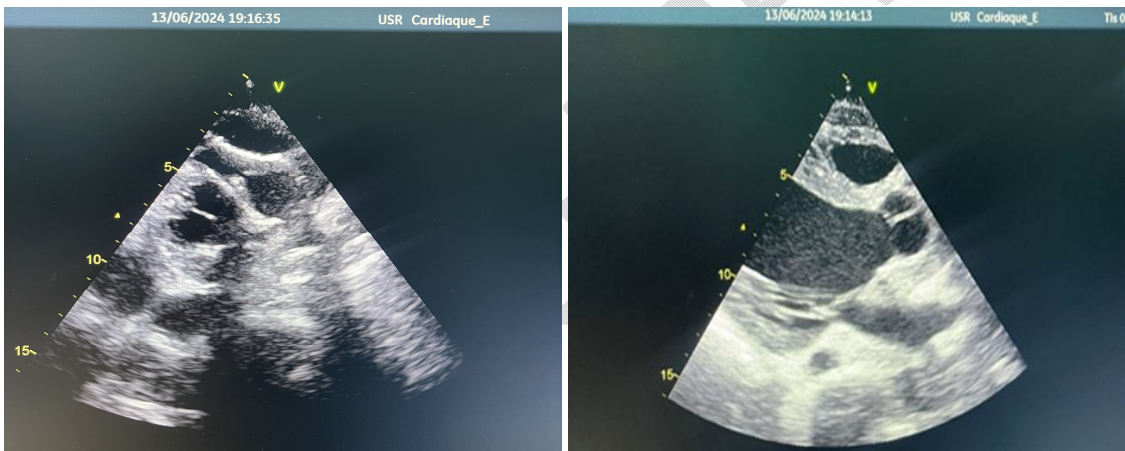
Post-operative evaluation of theaortic valve: parasternal long-axis and short axis views
